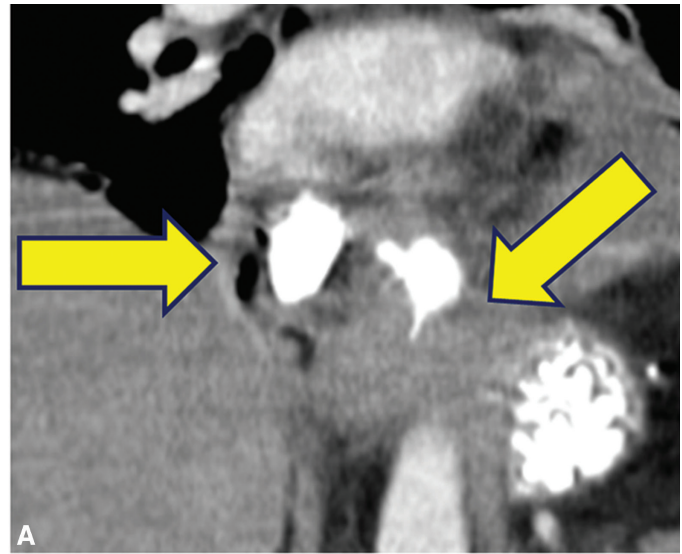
CT and esophagogram from a patient with a history of fundoplication representative of a false-positive CT. *A:* Coronal CT image with oral contrast shows apparent extravasation of contrast with loculated air collections (arrows) suggestive of perforation. *B:* Fluoroscopic esophagogram demonstrating blind-ending stomach pouches (arrows) in the postsurgical patient without evidence of perforation.
